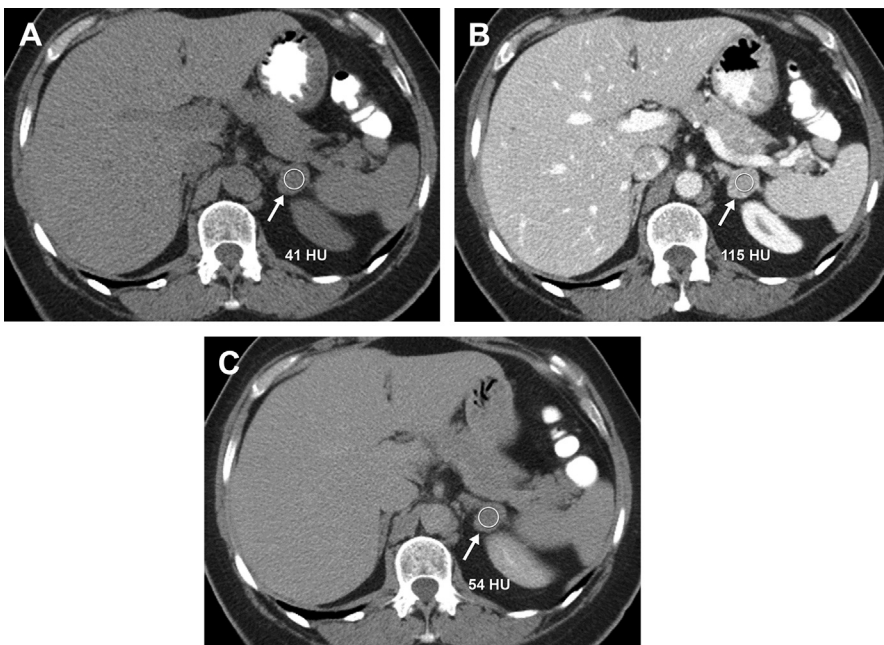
Lipid-poor adrenal adenoma on computed tomography (CT). Axial nonenhanced CT (A), contrast-enhanced CT in venous phase (B), and delayed 15 minutes (C), demonstrate a well-circumscribed oval mass (arrows) involving the left adrenal gland with an attenuation value of 41, 115, and 54 Hounsfield units (HU) on noncontrast, venous, and delayed phase imaging, respectively, yielding an absolute enhancement washout of 82%, characteristic of a lipid-poor adenoma.
